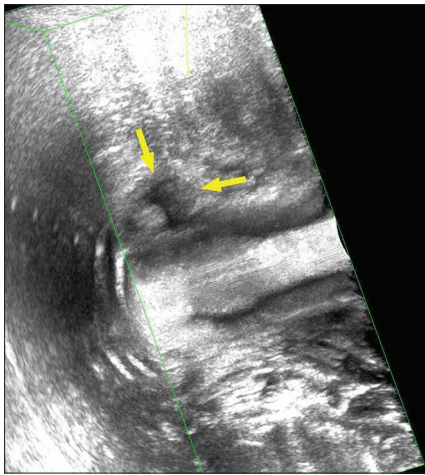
Three-dimensional endoanal ultrasound image of the perianal abscess
